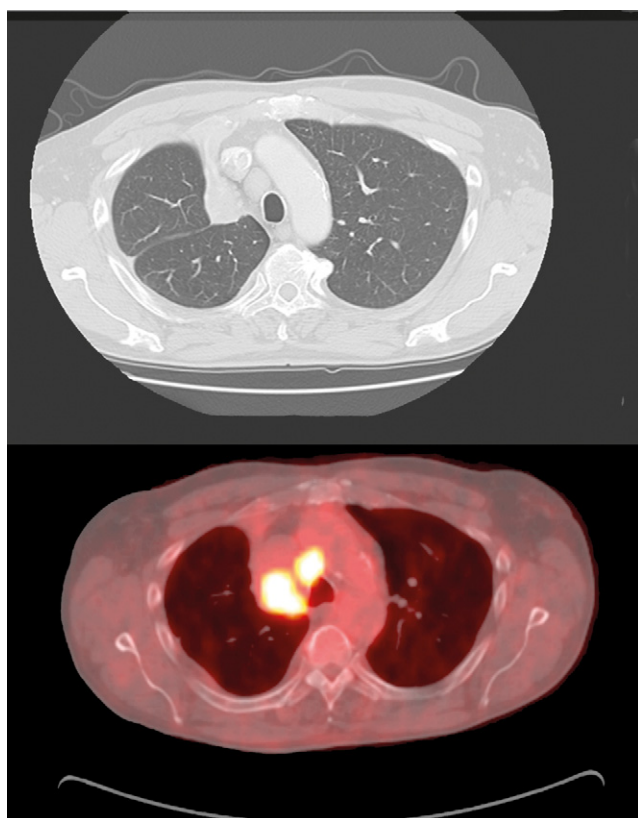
CT/PET of a patient with right upper lobe lesion. Bronchoscopy obtained Squamous cancerous cells. The high intake of ^{18}F FDG seen in pre-carinal node #3 was sufficient evidence not to proceed with mediastinoscopy. The patient was treated by chemo-radiotherapy.
